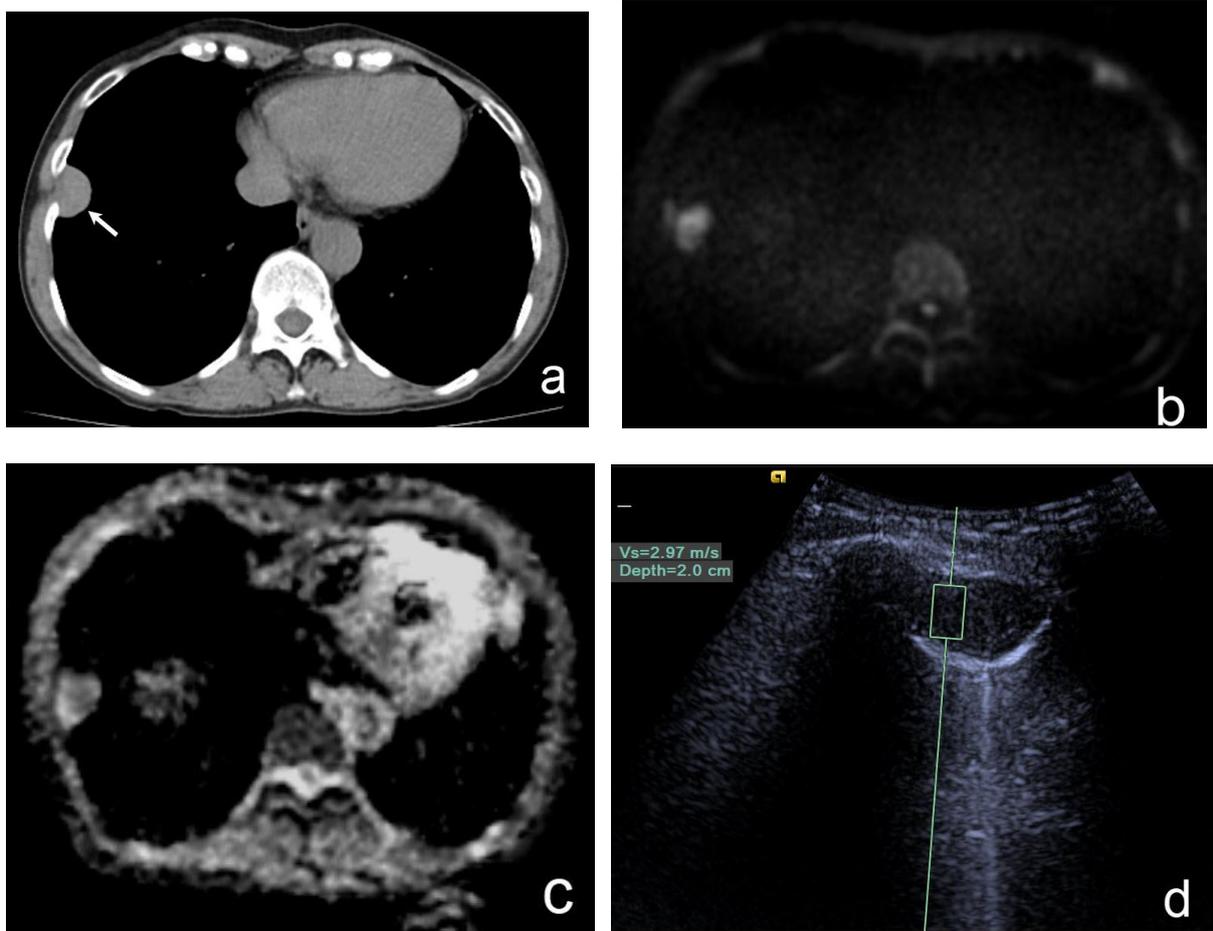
A 62-year-old smoker female with benign right pleural-based mass (solitary fibrous tumor). a. Axial CT image of the mass (arrow). Axial DWI (b) and ADC map (c). The mean ADC was $1.115 \times 10^{-3} \text{ mm}^2/\text{s}$ and minimum ADC was $0.3 \times 10^{-3} \text{ mm}^2/\text{s}$. The maximum SWV value is 2.97 m/s (d).
